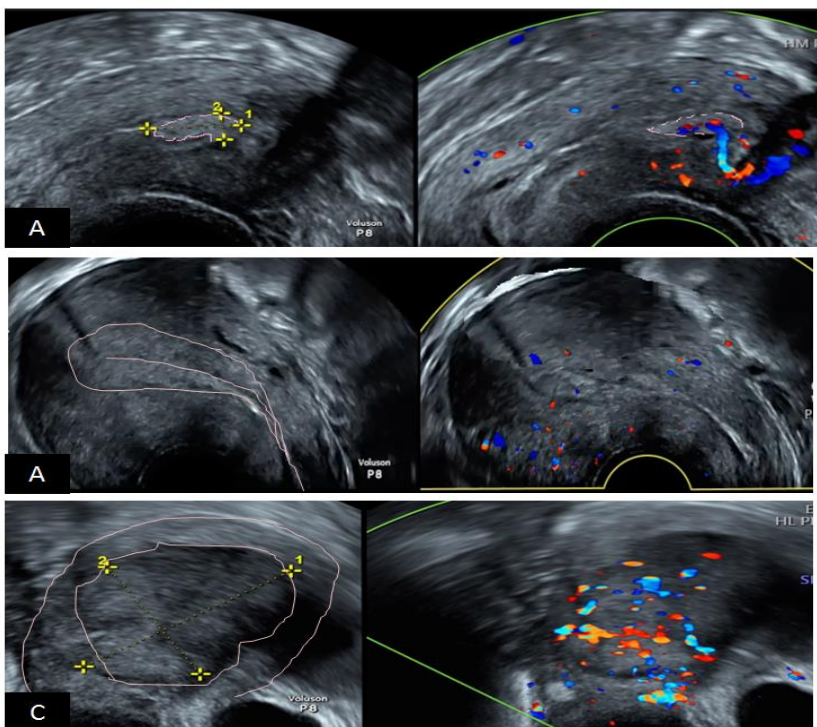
The International Endometrial Tumor Analysis (IETA) consensus opinion regarding the differential diagnosis between EP, EH and EM. A: endometrial polyp hyperechoic with a unique vascular pedicle; B: endometrial hyperplasia with moderate vascularization at Doppler; C: endometrial malignancy, thick image with intense hypervascularization at Doppler. Images by A. Drizi
